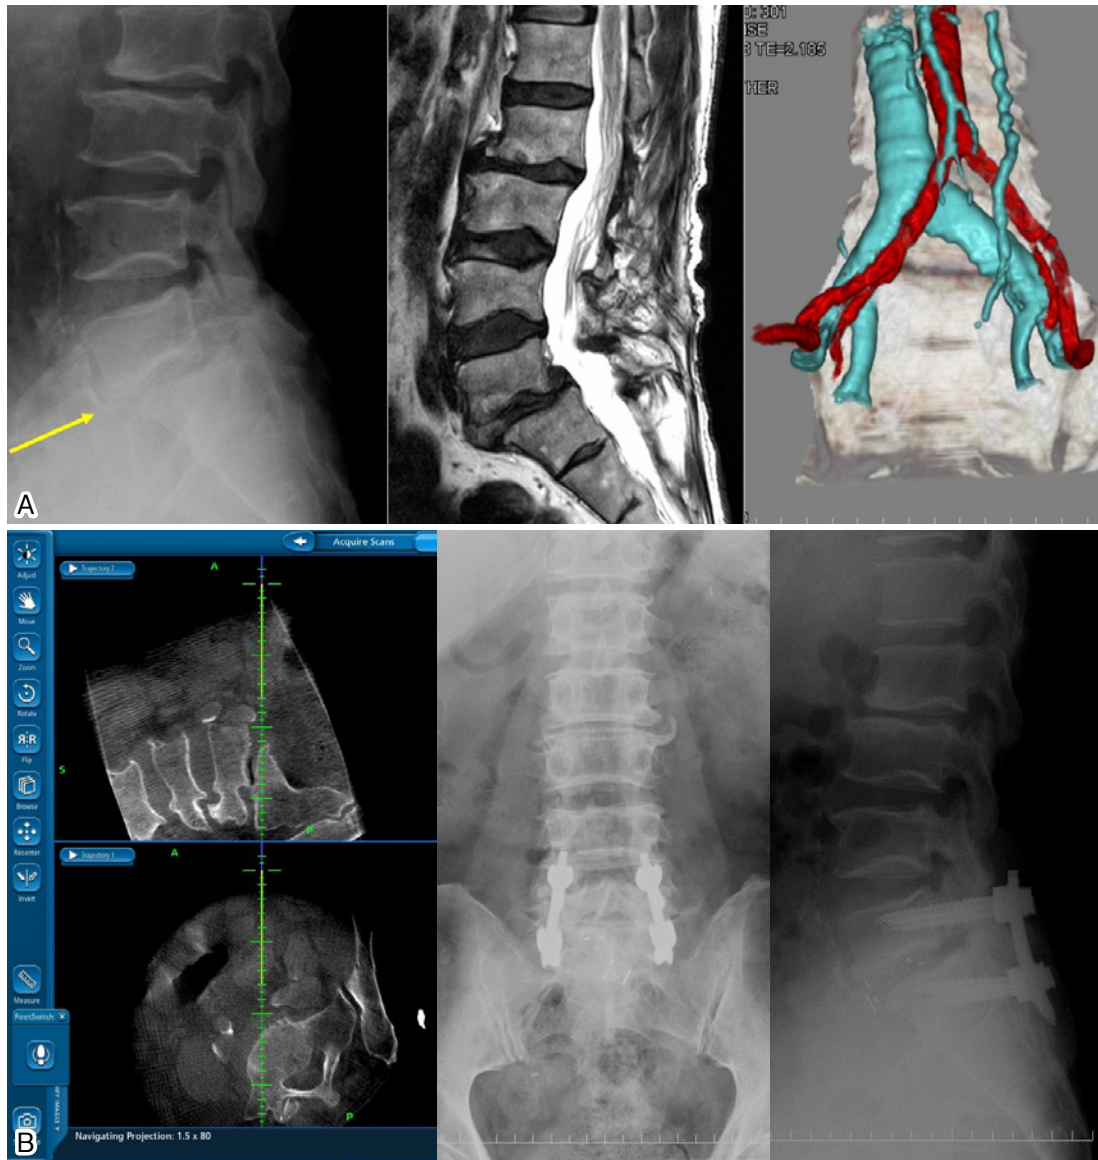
A: A 67-year old male, L5 isthmic spondylolisthesis. B: Successful OLIF at L5/S1 was performed using simultaneous posterior percutaneous screw fixation. The vein enhanced intraoperative CT helped the surgical approach effectively.
